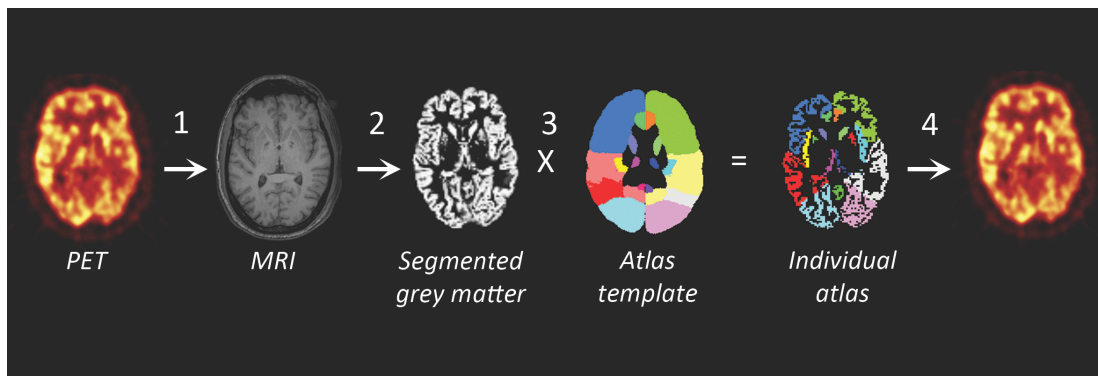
Atlas-based ROI analysis. 1. Co-registration of PET and MRI images. 2. Segmentation of MRI image. 3. Multiplication of a binary map created from the segmented grey matter MRI with the predefined atlas volume. 4. Application of the resulting individual atlas onto the co-registered PET image and extraction of regional values.
